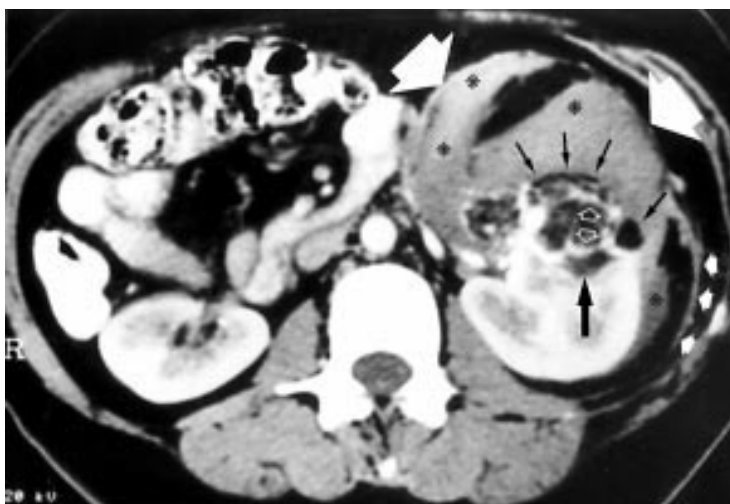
Abdominal contrast enhanced computed tomogram.
